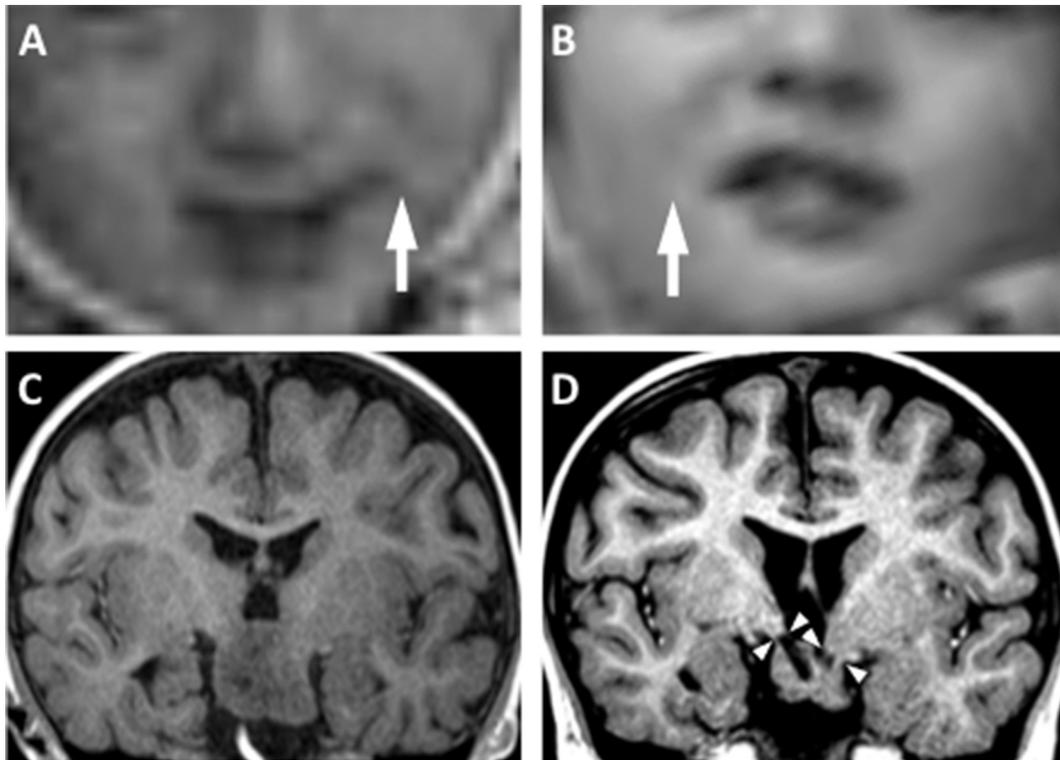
A case of asymmetric GS exhibited independently on both sides. A, B) Magnified pictures of lower-half faces exhibiting asymmetric GS (arrows), recorded independently on both sides. C) Preoperative MRI shows a giant HH with bilateral attachment. D) Complete disconnection (arrowheads) of bilateral attachments of HH is confirmed on postoperative MRI.
